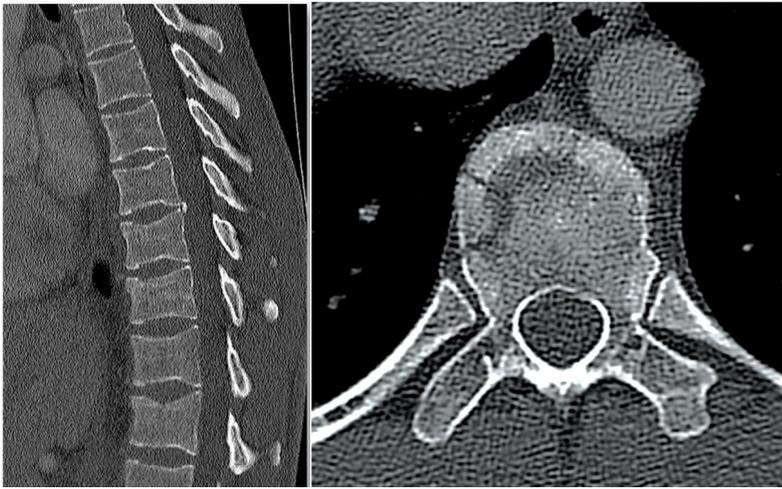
Wedge compression fracture (Single column injury, AO Classification: A1, TLICS Morphology Compression – score 1). Sagittal (1a), axial (1b) CT slices demonstrate a compression fracture in the lower thoracic spine involving the superior cortex. By definition there is no involvement of the posterior cortex of the vertebral body and there is only single (superior in this case) end plate involvement. MRI will not be required as this is a stable injury.
